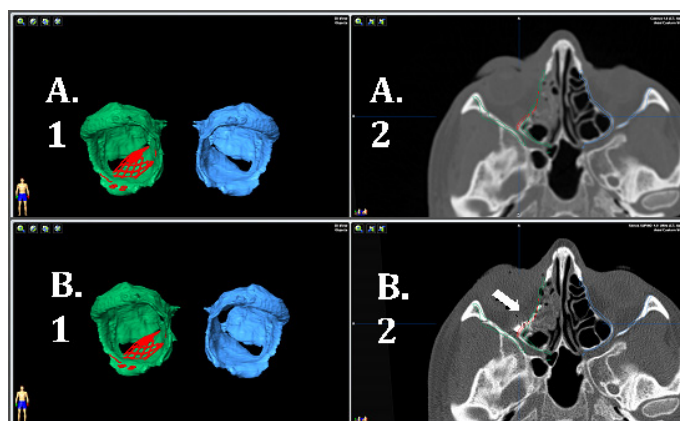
A.1-2. Orbital reconstruction plate (red), obtained from STL archives of custom made plate, reconstructing orbital walls and placed in the right position using virtual surgery. B.1. Virtual surgical plan. B.2. Post-operative CT scan. Reconstruction plate placed in the right position (white arrow) using navigation
